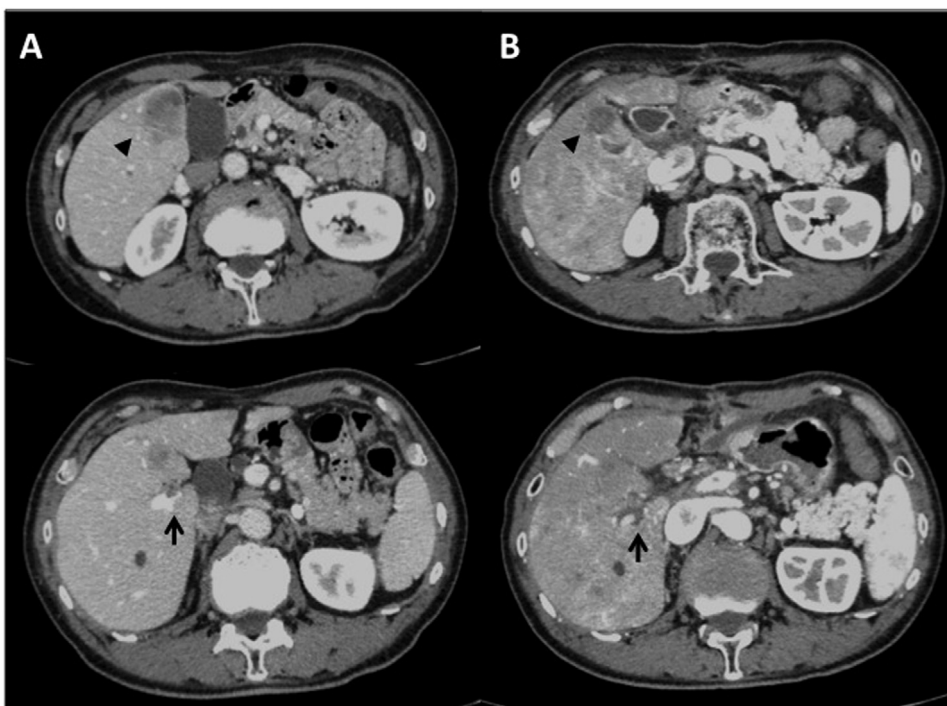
A) Contrast-enhanced computed tomography (CECT) scan 7 days after the initial CECT reveals tumor regression to 30 mm (arrowhead) in diameter and regression of portal vein tumor thrombosis (arrow). B) CECT findings 10 days after ligation of portal vein (PV). Tumor regression to 20 mm (arrowhead). Tumor thrombosis is no longer evaluable as a result of ligation of PV (arrow).
